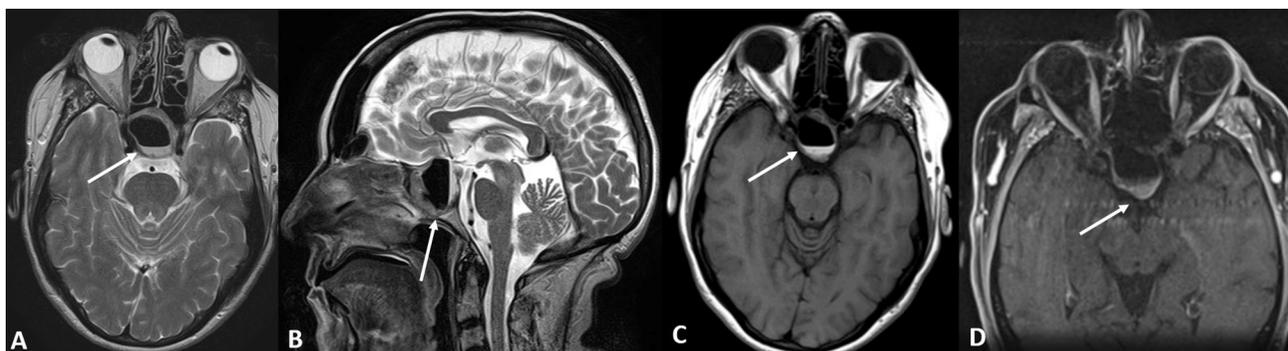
(A) Axial T2-weighted image demonstrates a large sellar lesion containing central cystic region with an air-fluid level. (B) Sagittal T2-weighted image shows the lesion extending from the floor of the sphenoid sinus to the optic chiasm. (C) Axial T1-weighted image demonstrates the fluid level to be of hyperintense signal indicating hemorrhage/blood products. (D) Following the administration of intravenous contrast, an axial T1-weighted, fat-saturated image revealed enhancement of the periphery/rim of the lesion.
